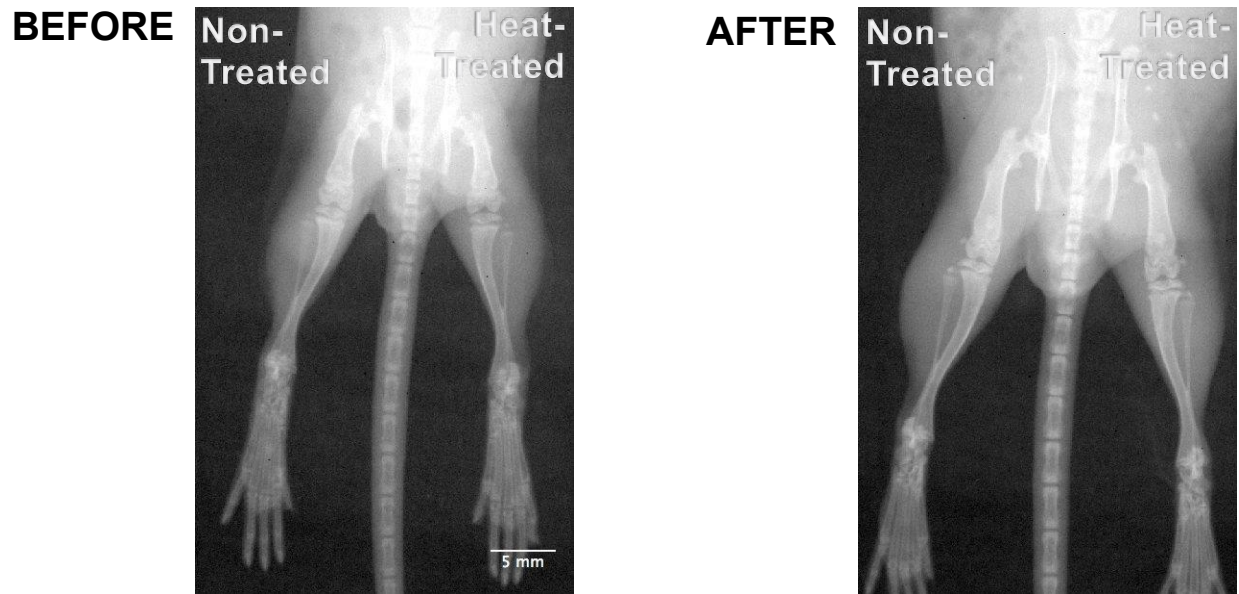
Radiographs Collected Before and After Unilateral Heat-Treatment
